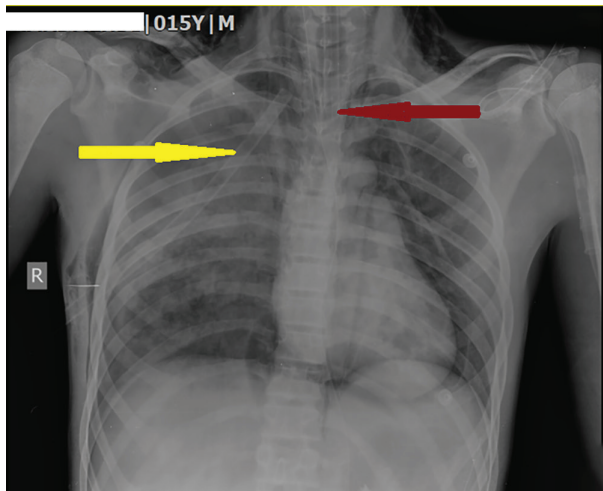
The second chest X-ray shows the exact positions of ETT (brown arrow) and chest tube (yellow arrow).
